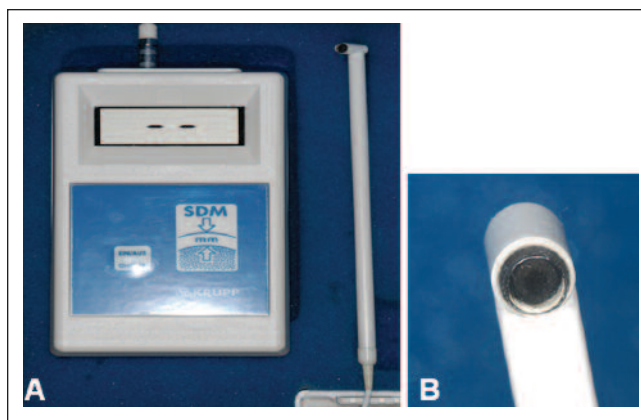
(A) SDM ultrasonic gingival thickness meter (KRUPP Corporation, Essen, Germany). (B) SDM's tip having 3 mm diameter.
